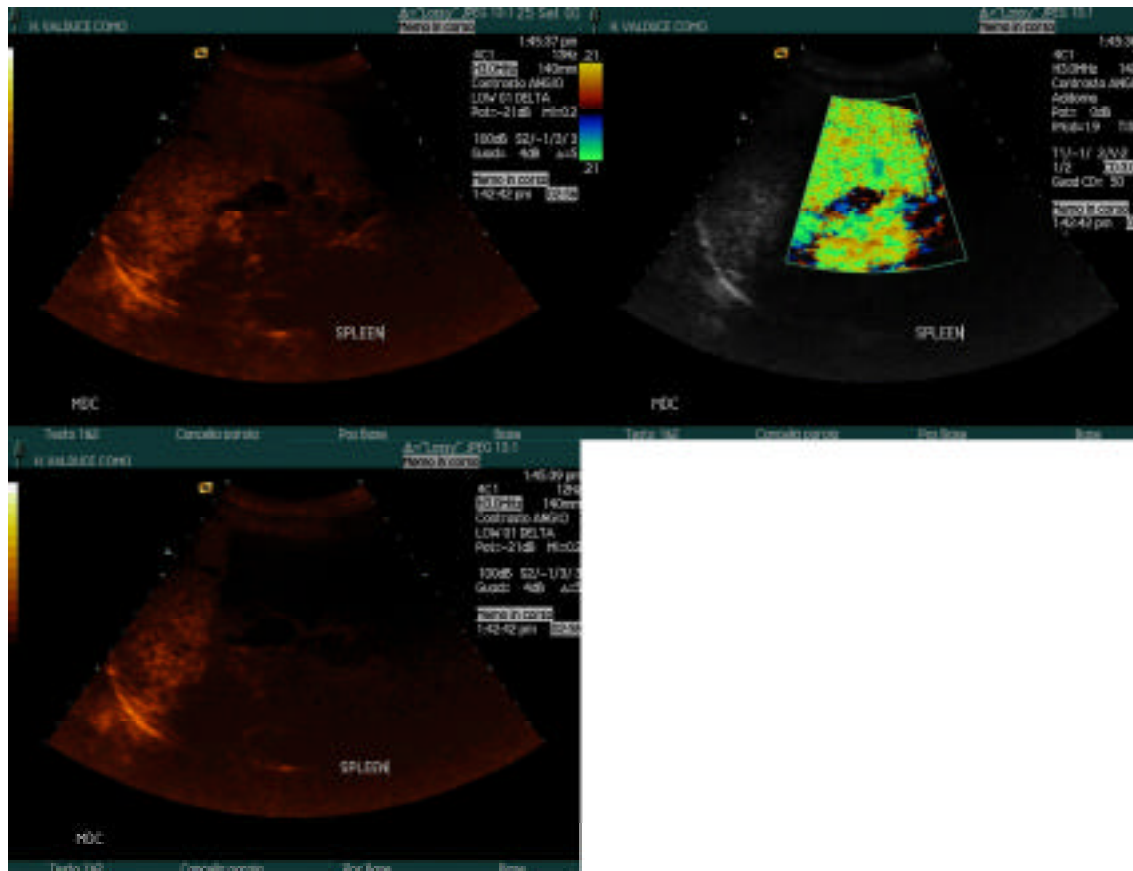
Baseline US images with VLMI of the spleen. The parenchyma is enhanced due to SonoVue™ effect. 2b- US images of the spleen parenchyma. Massive bubble destruction after SonoVue™ injection due to high power colour Doppler box (Stimulated Acoustic Emission) 2c – US images of the spleen with VLMI obtained immediately after bubble destruction. Part of the spleen parenchyma is almost without signal detectable and the rest is still enhanced (no bubble destruction).
